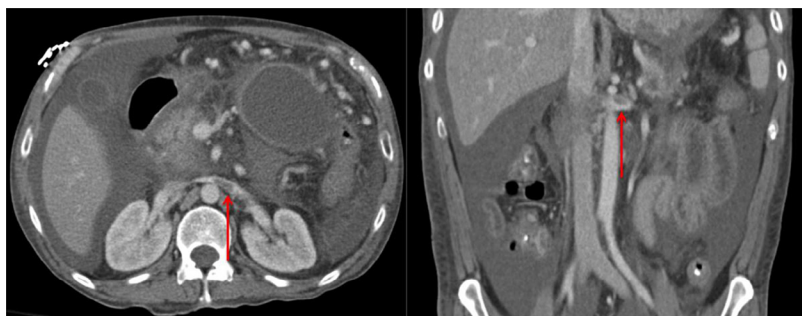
Nonocclusive renal vein thrombus. Contrast-enhanced axial and coronal computed tomography images of the abdomen demonstrate nonocclusive thrombus in the left renal vein (arrow). In addition, there is evidence of acute pancreatitis (pancreatic swelling and extensive peripancreatic fat standing), a rim enhancing intra-abdominal collection, and moderate volume reactive ascites.
